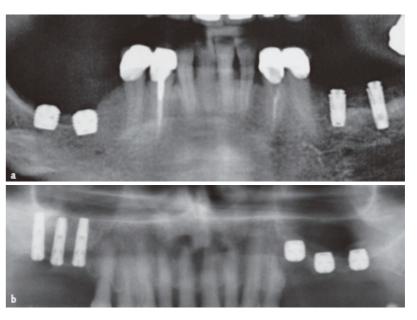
Panoramic radiographs after implant placement of two patients having their edntulous sites randomized to receive 5 mm-long implants or 10 mm or longer implants in augmented bone: a) mandible, b) maxilla
